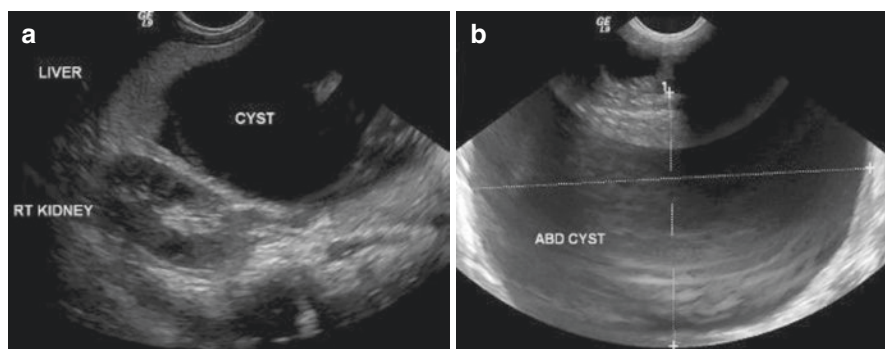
(a, b) Abdominal and pelvic ultrasound showing a large ovarian cyst
